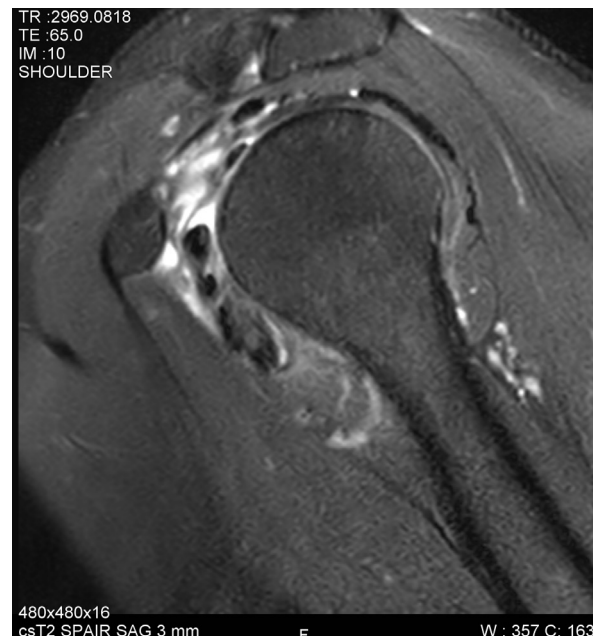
Sagittal section MRI fatsat images showing oedematous infiltrate of the rotator interval and fatty spaces adjacent to the inferior glenohumeral joint recess in coronal and of the rotator interval in sagittal.
